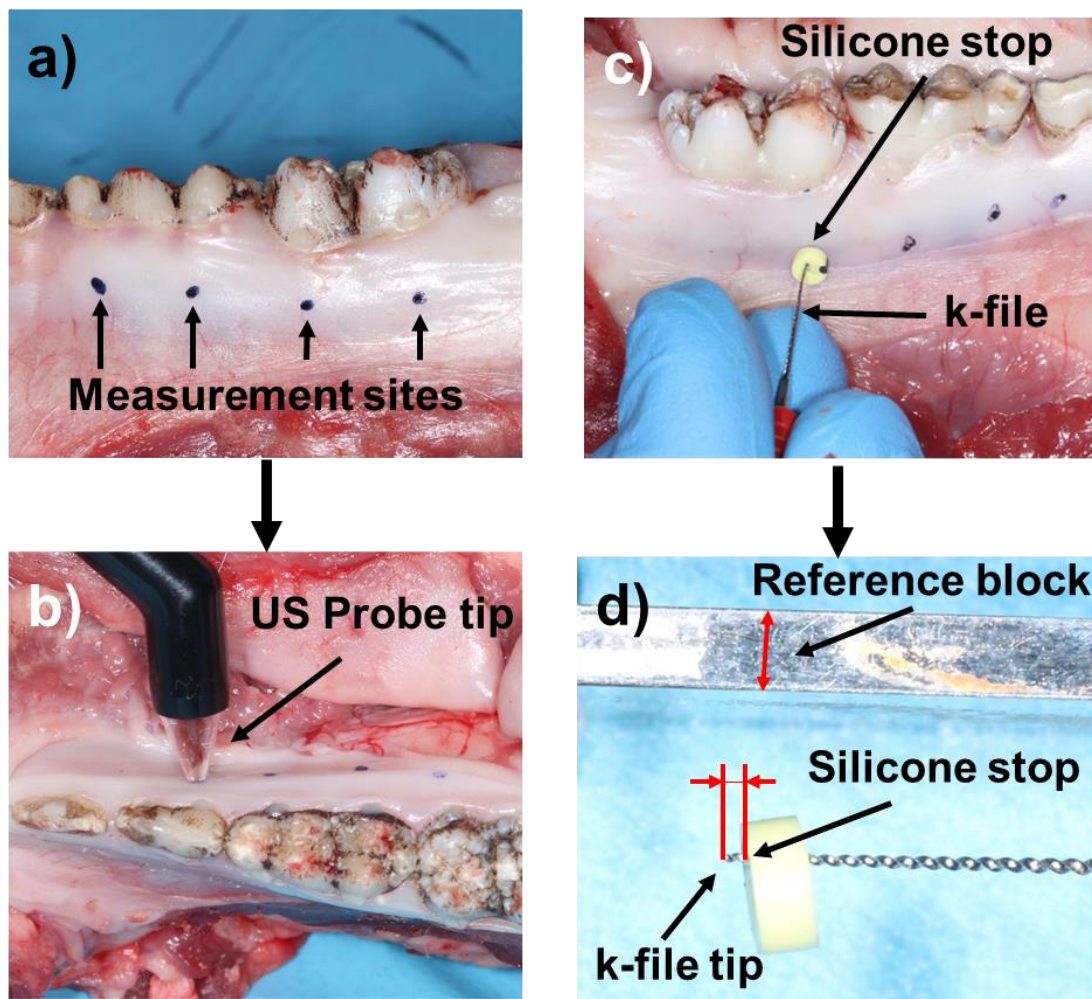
Methods used in the experiment: a) Marking of measurement sites on gingival tissue, b) Ultrasound (US) measurement at marked sites, c, d) TGP at marked sites with k-files and measurement using reference block.
